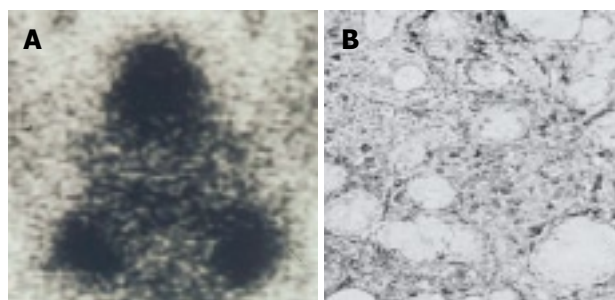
IgG4-related sclerosing sialadenitis. (A) Bilateral swelling of submandibular glands (Gallium scintigraphy); (B) Dense infiltration of IgG4-positive plasma cells in the salivary gland.
